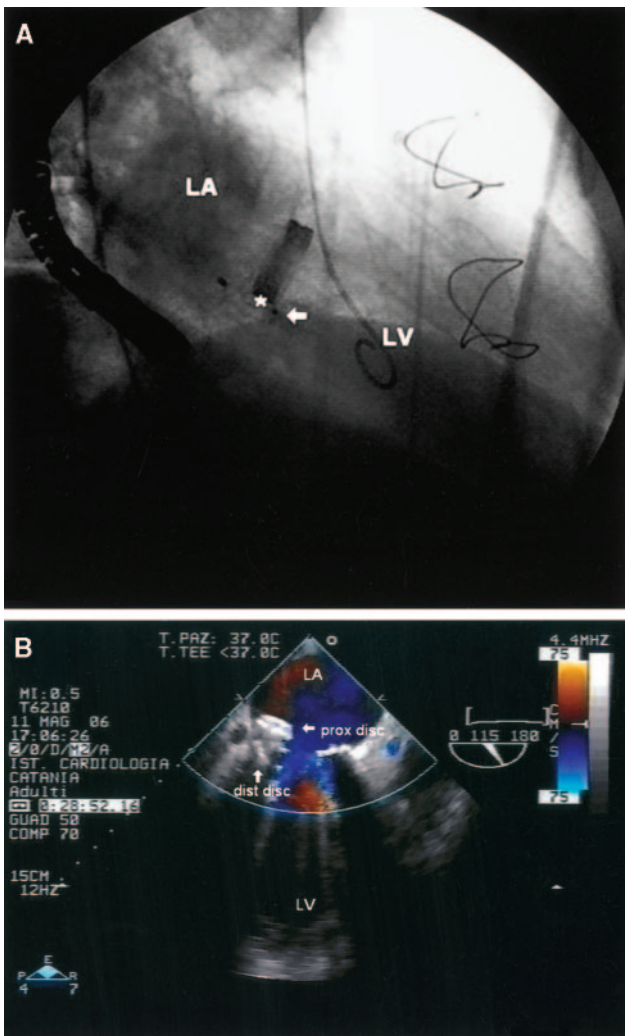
A, Fluorography acquisition after device placement in the paravalvular leak (*). B, Transesophageal echocardiogram, long-axis view. Note the position of the distal disc entrapped inside the leak, without any residual regurgitation or leaflet motion interference. LA indicates left atrium; LV, left ventricle.
